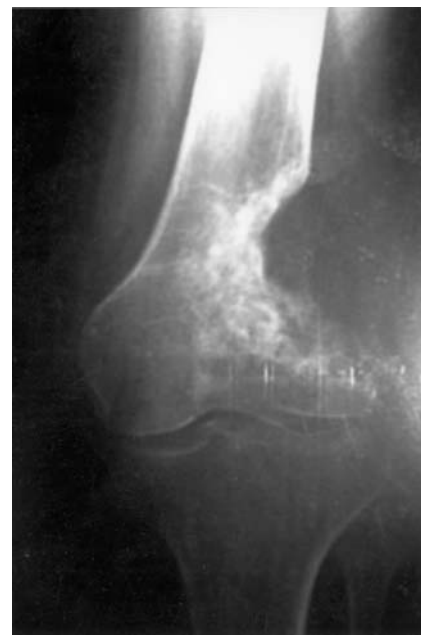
Post-operative plain x-ray for the same patient after curettage, cryosurgery and bone graft (using bone chips from the iliac crest).
